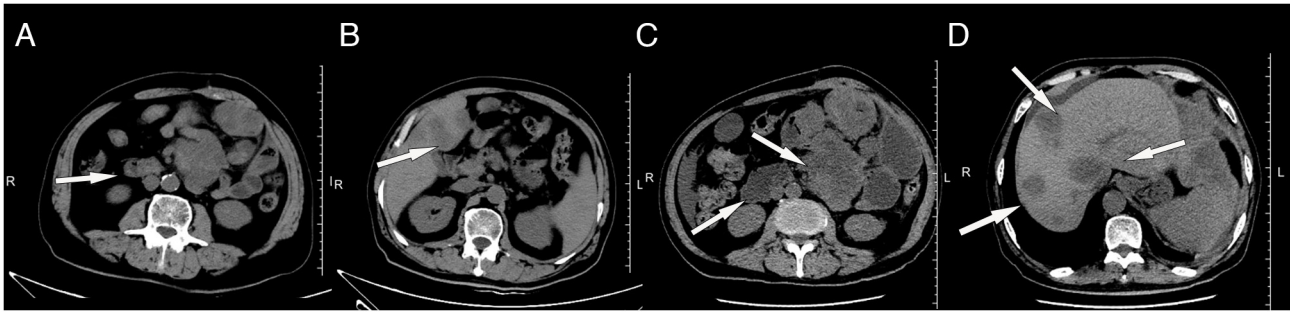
Abdominal CT scans of the 57-year-old male patient with multiple small intestinal metastases from lung cancer. (A) CT revealing multiple metastatic masses on the small intestinal wall 2 months after surgery. (B) CT revealing multiple metastatic low-density lesions in the liver 2 months after surgery. (C) The final CT indicating multiple large metastases on the small intestinal wall. (D) The final CT indicating multiple large metastases in the liver. The white arrows point to the metastatic tumors. CT, computed tomography.
